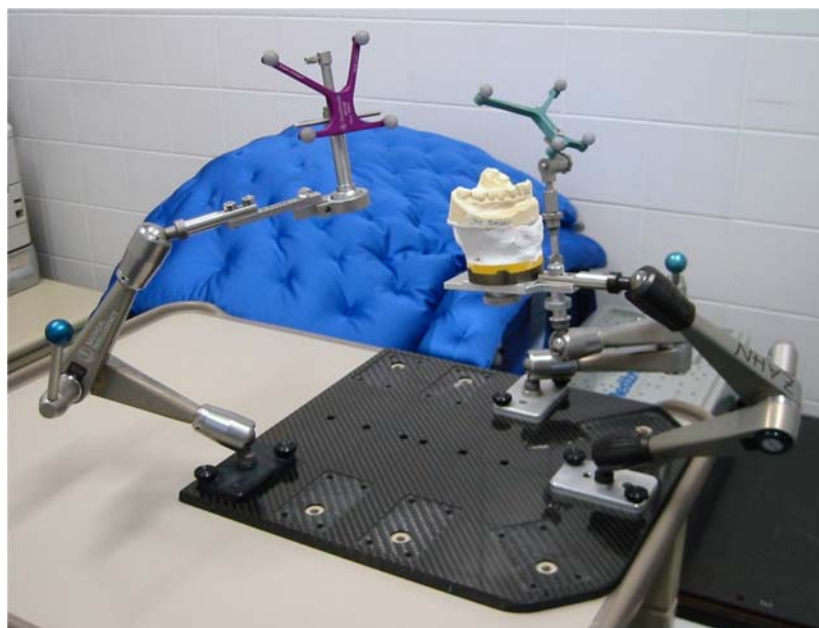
CT-guided template fabrication using a navigation system. Laboratory set-up consisting of a base plate with multiple fixation areas for the mechanical arms, mechanical arm holding the unmodified dental stone cast of the patient (right), DRF of the navigation system (background) (StealthStation Treon plus, Medtronic Inc., Louisville, USA), and the EasyGuide aiming device (left).
